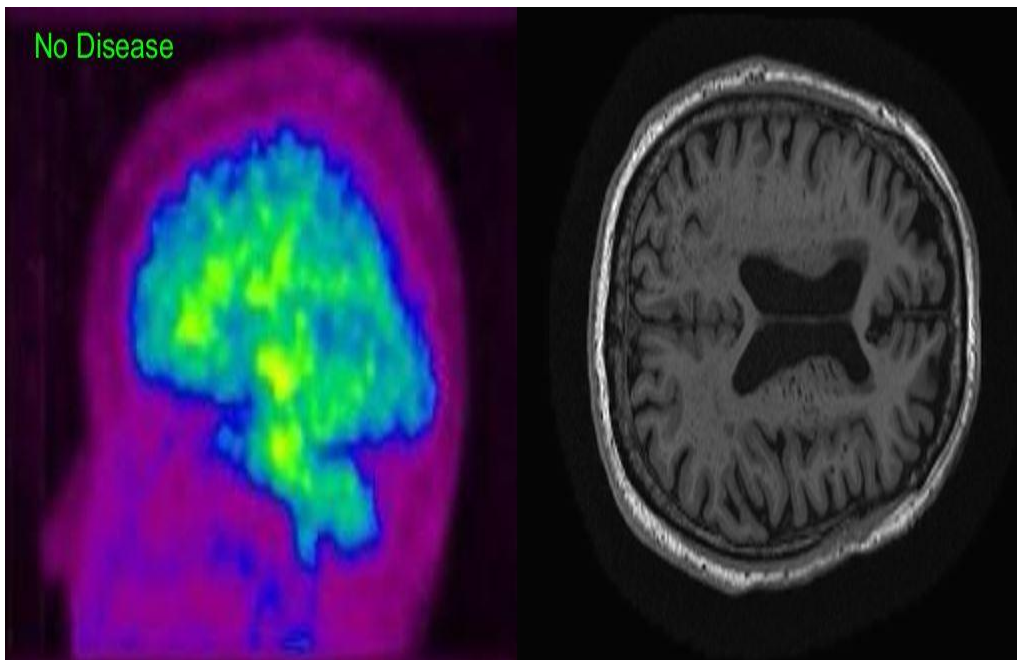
PET and MRI image having non alzheimer's disease is correctly classified under the class of no disease.
